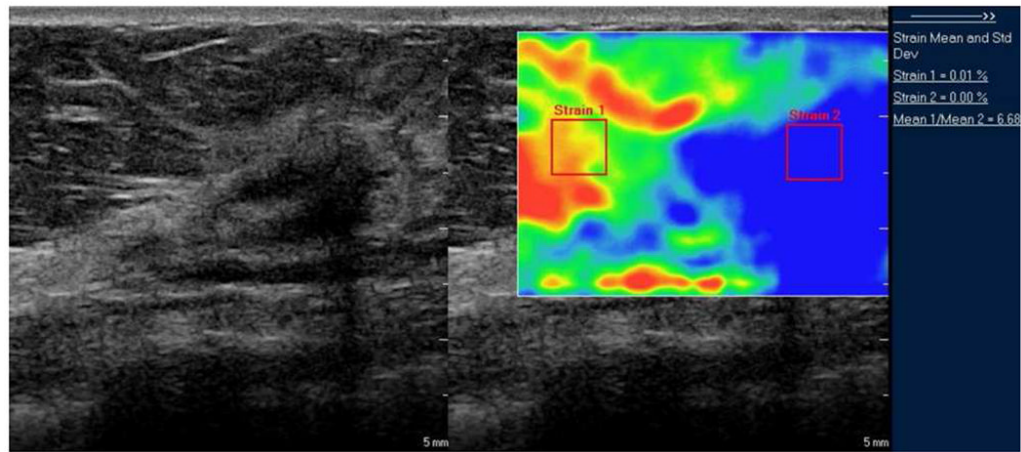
Strain ratio computation. Sonogram of breast lesion on left with color elastogram on right. The ratio of strain within the lesion (strain 2) and adjacent to the lesion (strain 1) is computed as 6.68
